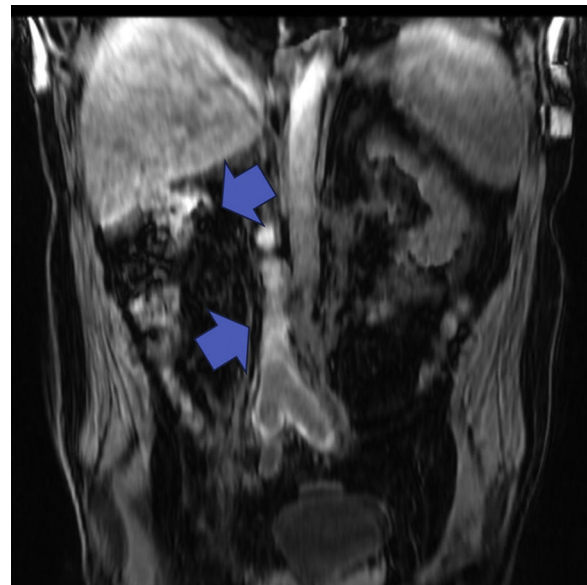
MRI: Thrombosis at the level of the ilio-caval axis. Right renal agenesis and absence of intrahepatic IVC.
